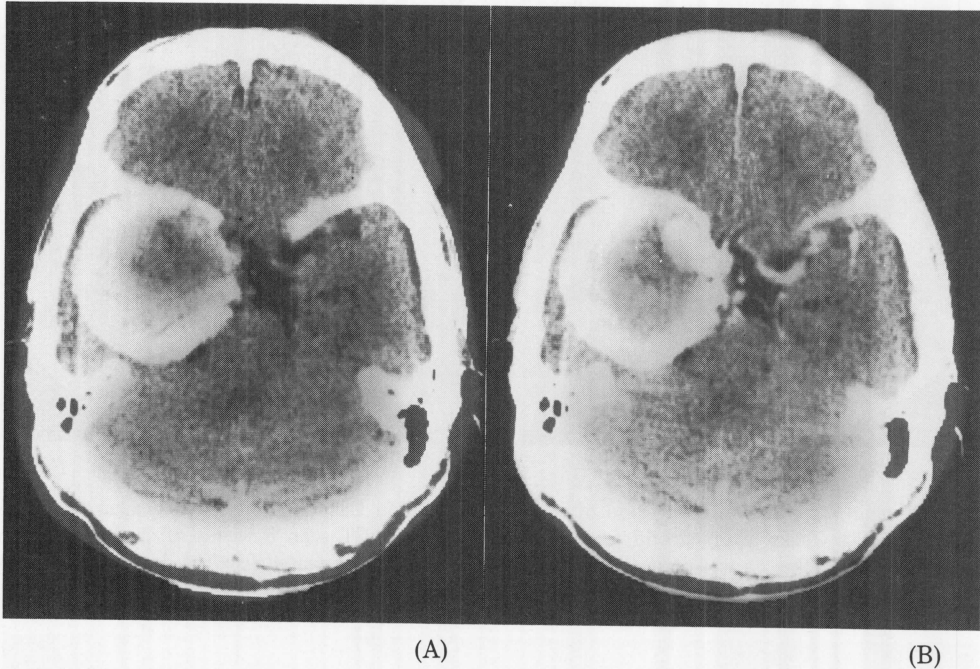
CT scans obtained in 1982 on admission demonstrate a giant aneurysm measuring $6 \times 6 \times 7$ cm in size in Case 2. Plain CT scan (A) shows a spherical lesion with a partially calcified capsule occupying a substantial part of the left middle cranial fossa. Postcontrast scan (B) shows enhancement of an eccentric area and a rim of peripheral region.
